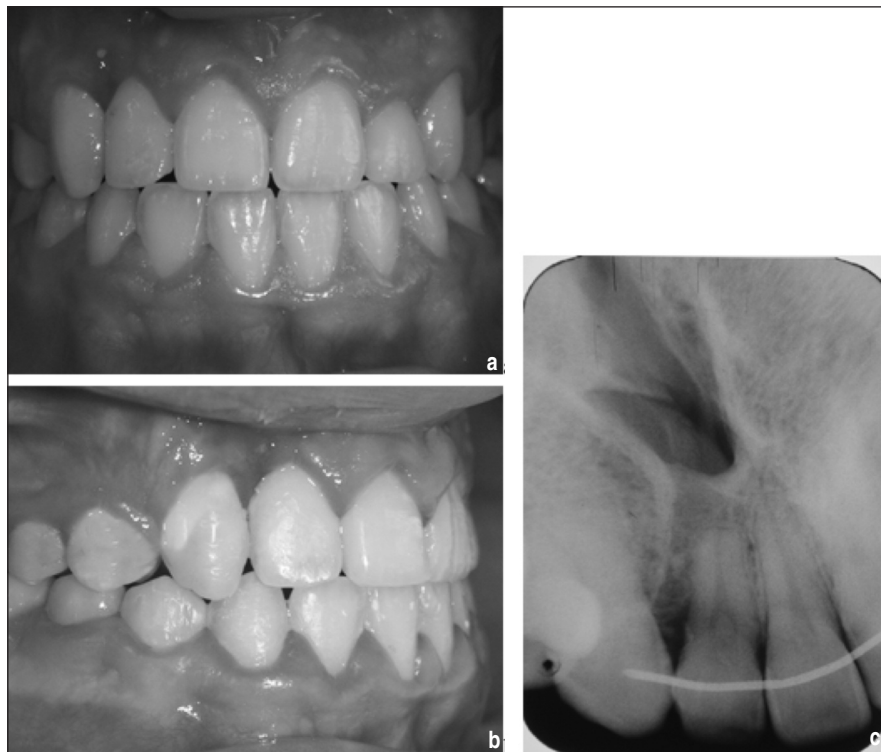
Post-treatment records. a and b. Intraoral photos showing the defect region; c. Periapical radiographs showing good bone material on the cleft side.
